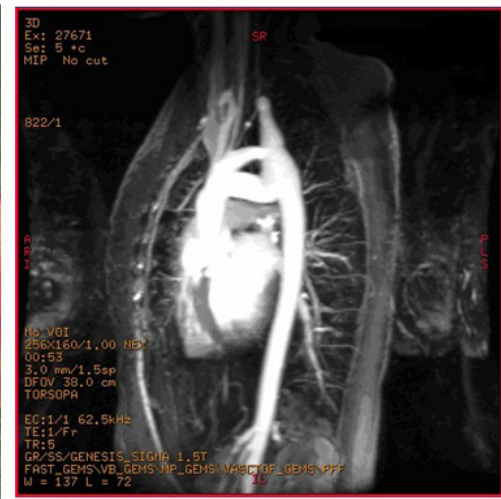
Final aspect of the operation with Dacron prosthesis anastomosed to the aortic arch; 2b – Magnetic resonance imaging on the 30th postoperative day, evidencing the well-positioned Dacron prosthesis
